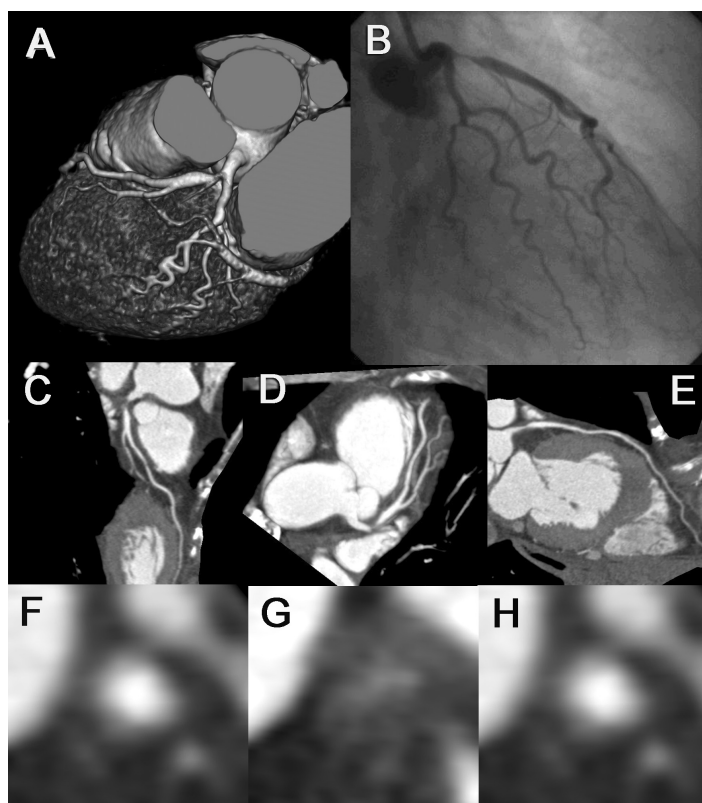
CT coronary angiogram and corresponding conventional angiogram of the left coronary artery in a patient presenting with unstable angina. Note that the volume-rendered images (A) provide an excellent anatomic overview of the coronary arteries but should not be used to score the presence and degree of coronary stenoses. Two detailed curved multiplanar reconstructed (cMPR) CT image (C, E) and a maximum-intensity projection reveal the presence of a significant stenosis located at the proximal LAD, which was confirmed on the conventional angiogram (B). Cross-sectional CT images show a large noncalcific plaque (G) and a normal coronary lumen of the left main (F) and distal LAD (H).
